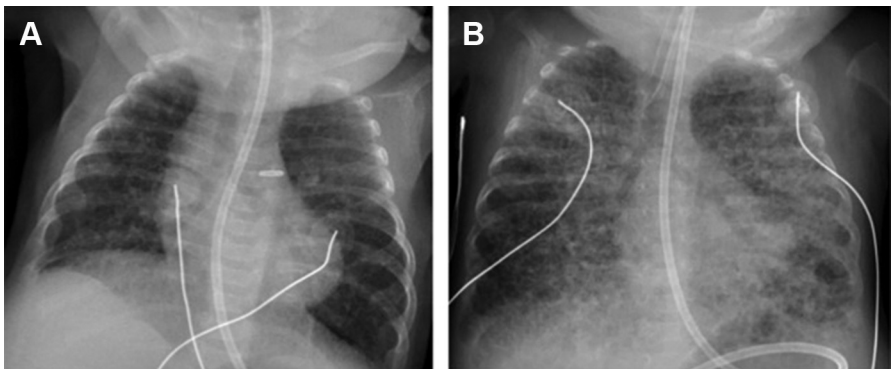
Chest radiographs of infants born at 23 weeks gestation (A) and 26 weeks gestation (B), both obtained at 36 weeks PMA. Infant A remained on noninvasive positive pressure ventilation and less than 30% FiO_2 , whereas infant B remained intubated with 40% to 50% FiO_2 . Therefore, both met criteria for severe BPD. (Data from Jobe AH, Bancalari E. Bronchopulmonary dysplasia. *Am J Respir Crit Care Med* 2001;163(7):1723–9.)
